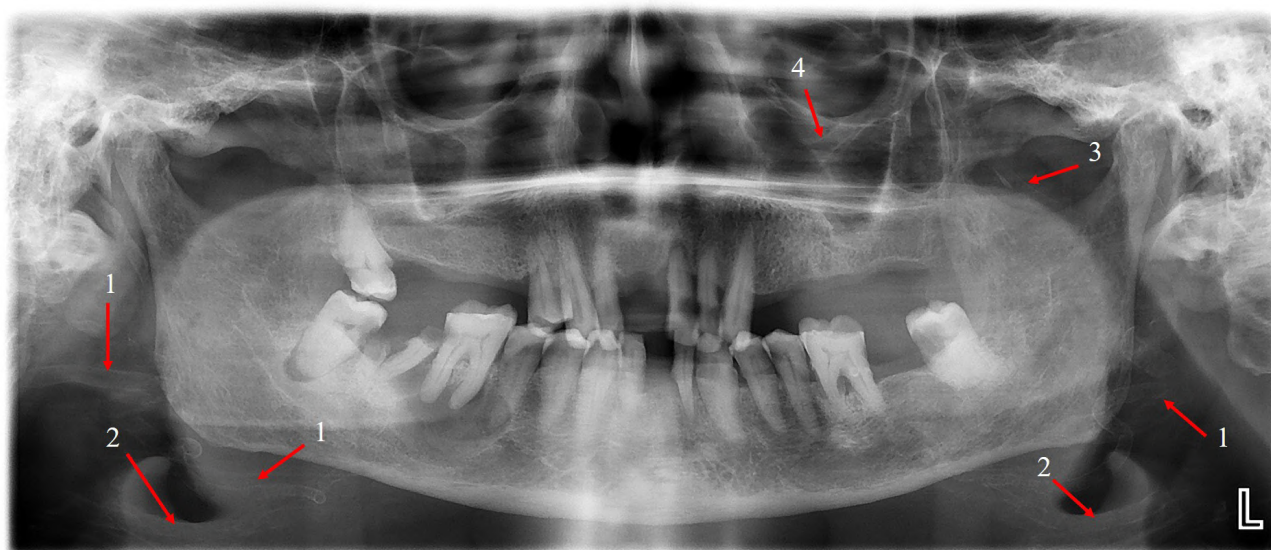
Panoramic radiograph shows the tracing of calcification. - Arrow 1 denotes a facial artery; Arrow 2, a lingual artery; Arrow 3, a maxillary artery; and Arrow 4, an infraorbital artery.
